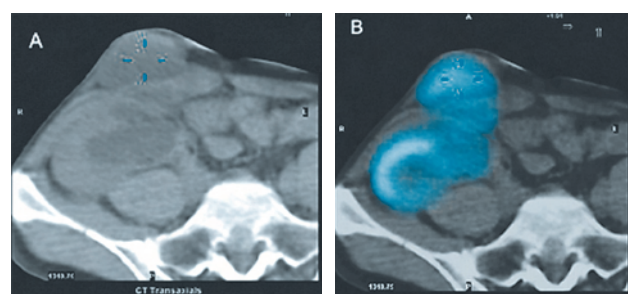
Trans-axial SPET CT images (A-CT image, B-SPET/CT fused image) show tracer activity both in the intra-abdominal and subcutaneous fluid collections confirming the diagnosis of urinomas.
